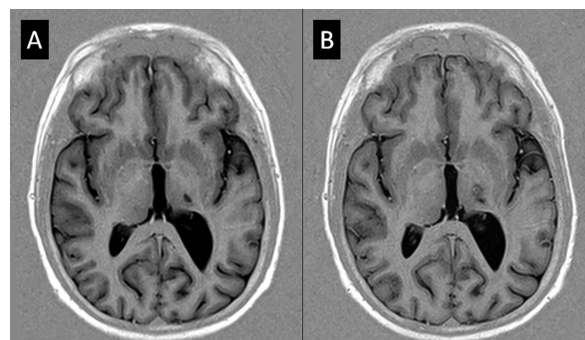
Magnetic resonance imaging turbo inversion recovery axial slices. (A) Before surgery, the infarction in the ventral posterolateral left thalamus is observed. Some ipsilateral cerebral hemisphere atrophy with enlarged lateral ventricle is also present. (B) One week after VIM thalamotomy. The surgical lesion was located dorsally, medially, and anteriorly to the thalamic infarction.
